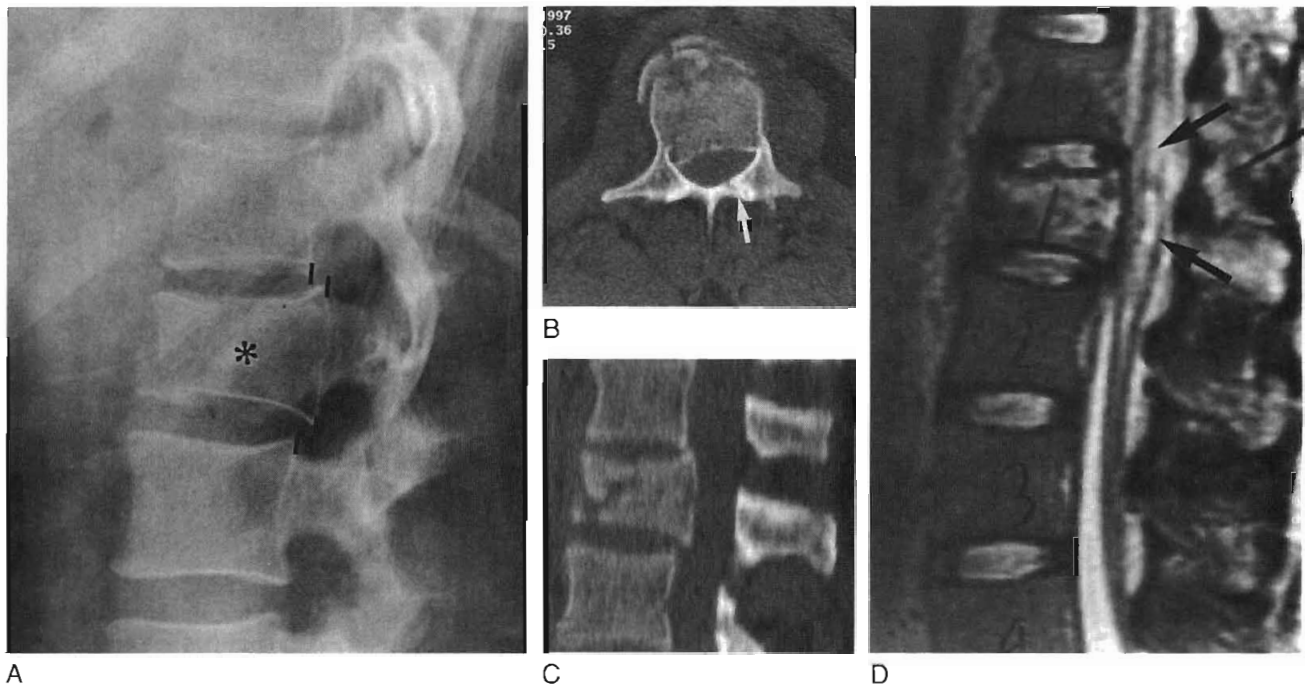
Post-traumatic vertebral body compression fracture. *A*, Lateral plain film of the thoracolumbar junction reveals a compression fracture involving the L1 vertebral body (*asterisk*). The decreased height of the vertebral body and the inferior anterior corner fracture are well seen. The retropulsed body can also be seen when the outline of the adjacent vertebral bodies (*lines*) are compared. *B* and *C*, Axial (*B*) and sagittal reconstructed (*C*) CT scans of the same patient add substantial detail to the degree of canal narrowing secondary to the retropulsed fragment. A left laminar fracture (*arrow, B*) is also seen, which was not apparent on the plain film. *D*, Sagittal T2-weighted MRI demonstrates the compression fracture of L1 and the retropulsed posterior body, as well as contusion and swelling of the conus (*arrows*) as a direct result of the compression fracture.
